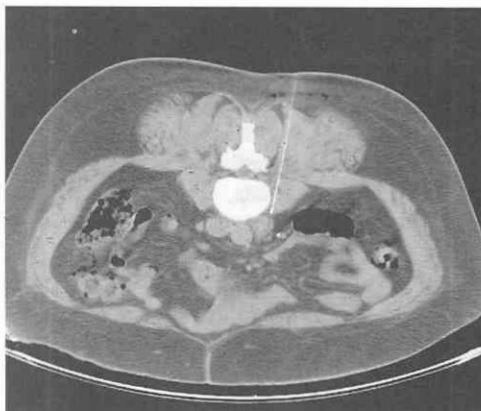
Lymph nodes adjacent to aorta are only suited for CT guidance because of the accuracy required.
